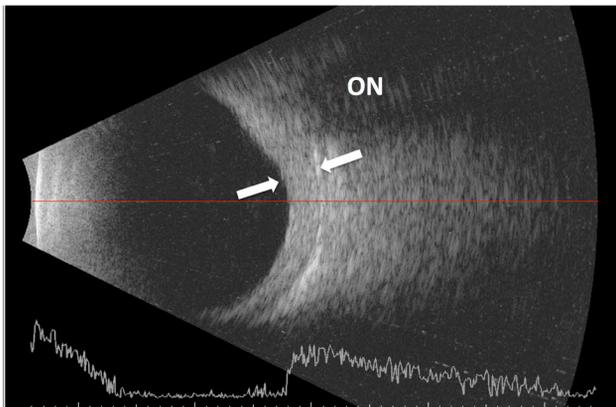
B-scan ultrasound image of the left eye. The white arrows indicate the thickened and congested choroid and sclera. The axial length is short, measuring 19.32 mm.
